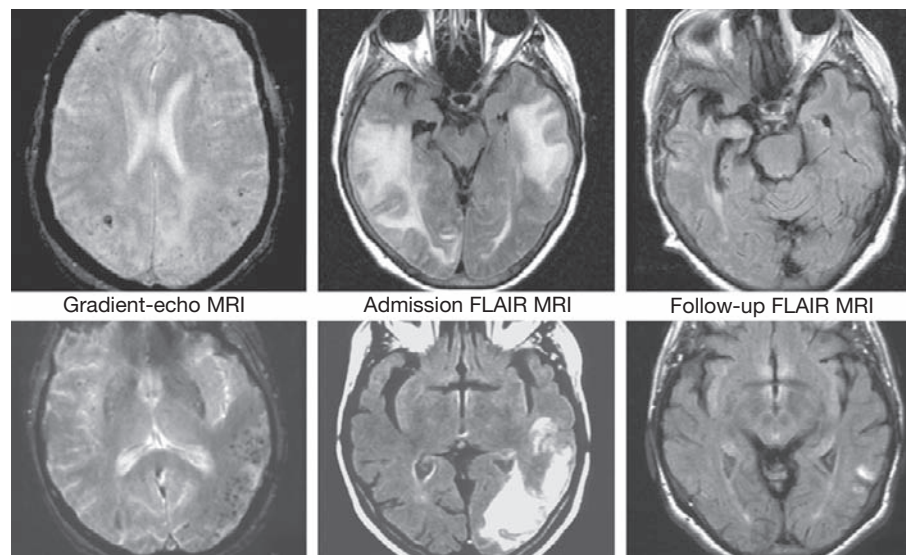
Amyloid-angiopathy-related inflammation. Magnetic resonance imaging (MRI) appearance in patients with cerebral amyloid angiopathy (CAA)-related inflammation, managed with immunosuppressive treatment. The gradient echo images from patients 1 and 2 show multiple small hypointense lesions characteristic of CAA-related microhemorrhages. The fluid-attenuated inversion recovery (FLAIR) images performed at presentation and after follow-up intervals of 2 months (Patient 1) or 22 months (Patient 2) demonstrate confluent regions of white matter hyperintensity that largely resolve at follow-up.
